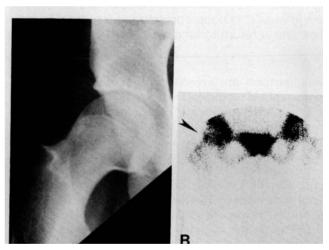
A, normal radiograph in patient with tension-side femoral neck stress fracture. B, positive tension-side stress fracture on bone scintigraphy.
